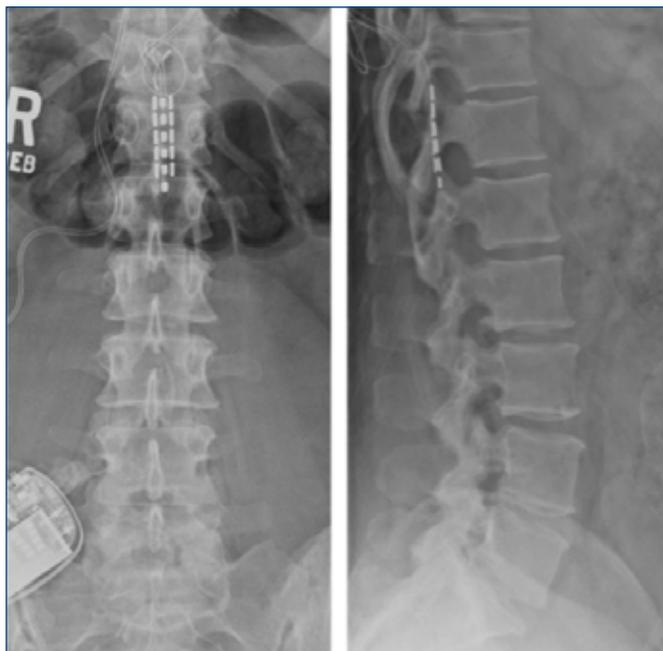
Plain AP and lateral radiographs of spinal cord stimulator implant in place, with pulse generator located within the right buttock subcutaneous tissue and leads placed in the dorsal epidural space at T12.
